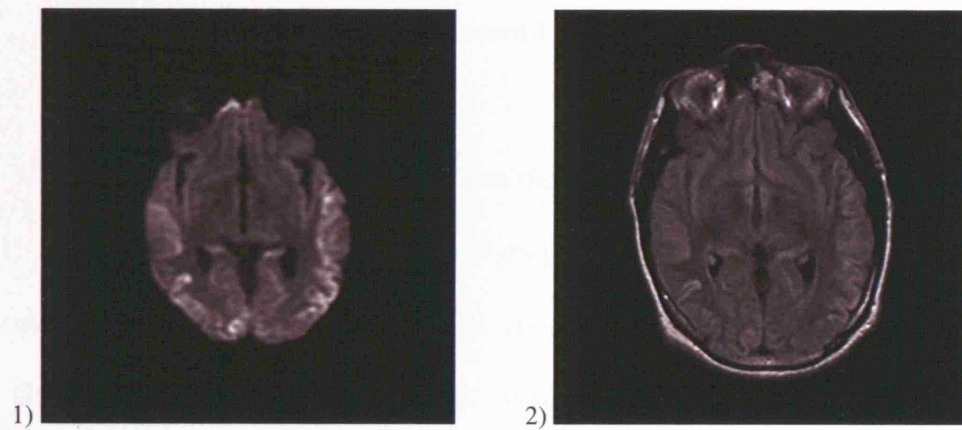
1) DWI and 2) FLAIR sequences in patient 16 with sCJD
